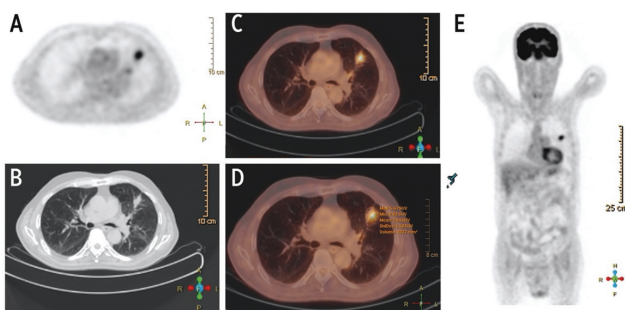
A spiculated and solid solitary pulmonary nodules was detected in left upper lobe in positron emission tomography (PET) image. (A) Axial non-contrast Thorax computed tomography (CT) at parenchyma window (B), and PET/CT image (C). Measurement of activity parameters were consistent with malignancy on PET/CT image (D). MIP image of total body PET showed significant activity in left upper lobe (E)
